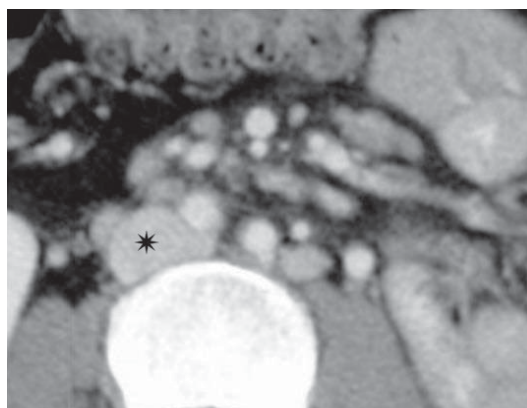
Computed tomography. Retroperitoneal lymph node metastases after radical prostatectomy. Enlarged lymph nodes are recognizable at the level of the root of the mesentery and with retroperitoneal aortocaval and right paracaval location. The largest lymph nodes are located at this site (*asterisk*)
